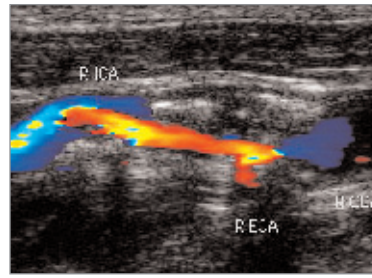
Ultrasound image of carotid plaque (red) and narrow artery. Image courtesy of Tristram Clinic, Hamilton, NZ.
